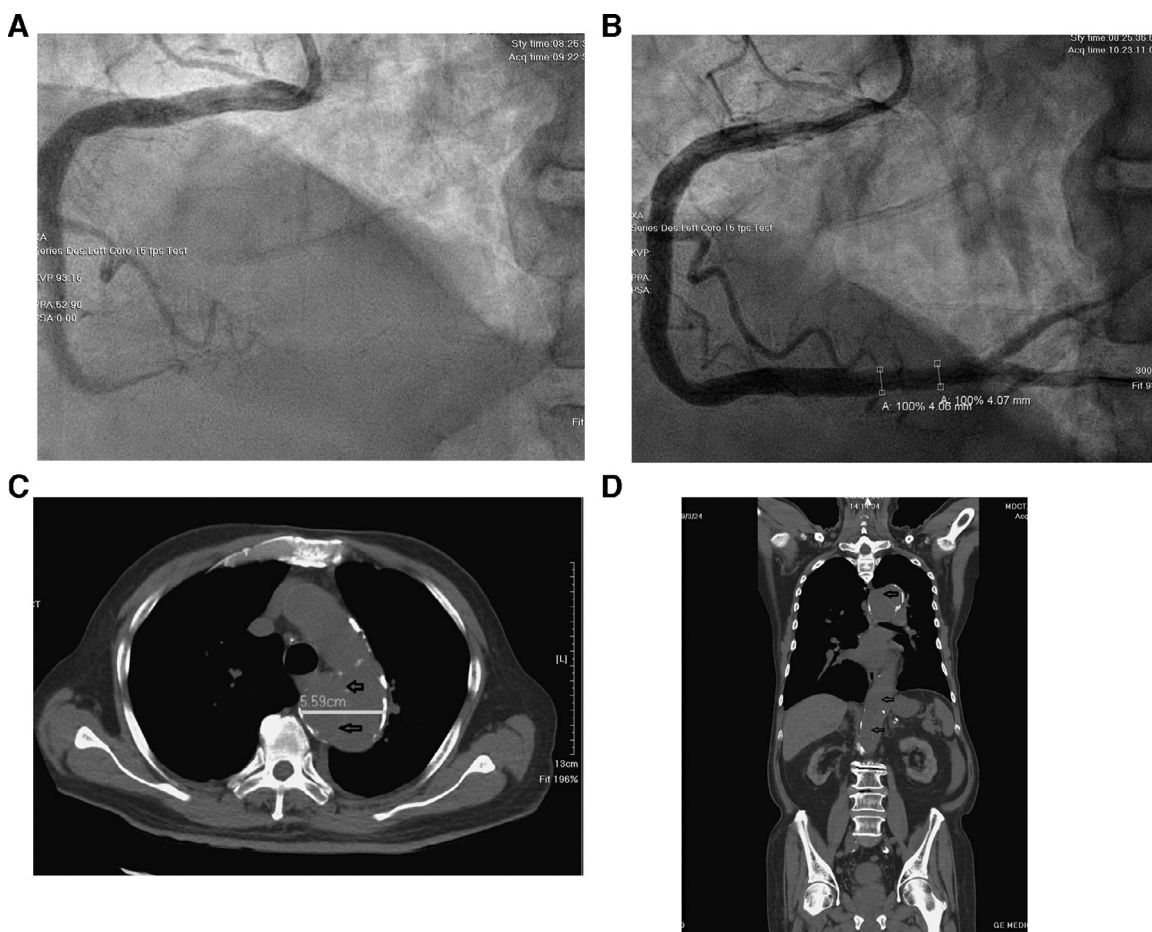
(A) Right coronary artery angiogram shows a distal occlusive lesion. (B) Right coronary artery revascularization by percutaneous coronary intervention (drug-eluted stenting). (C) Noncontrast multi-detector computed tomography shows complex aortic dissection and large aneurysm at the aortic arch; black arrows indicate intimal flaps; green line indicates largest aortic diameter of 5.6 cm at aortic arch level. (D) Noncontrast multi-detector computed tomography shows the descending thoracic and abdominal aorta dissecting aneurysm; black arrows indicate intimal flaps.
